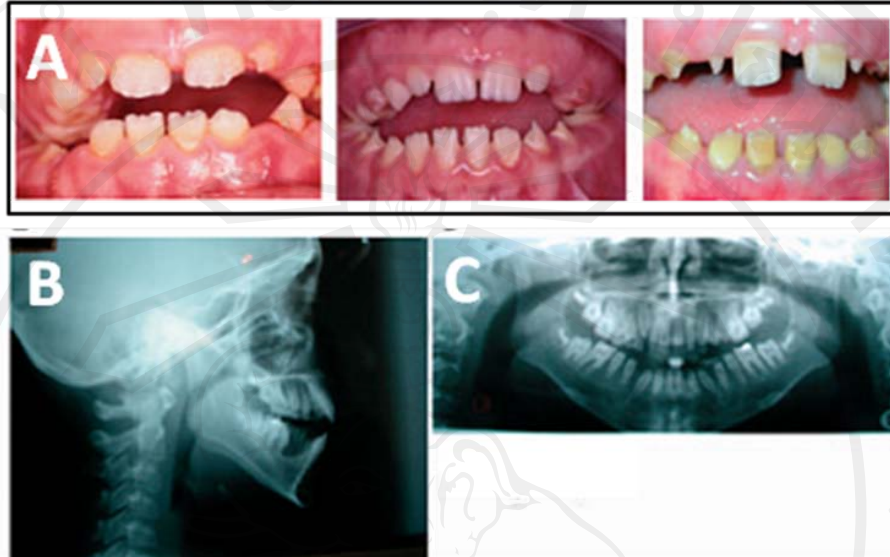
(A) Three probands from different families shows generalized hypoplastic enamel with clinically anterior openbite malocclusion. (B) The cephalometric radiograph in one of the proband shows anterior open bite. (C) The panoramic radiograph shows generalized hypoplastic enamel with reduction in radiodensity of enamel (Hart et al., 2003b).
